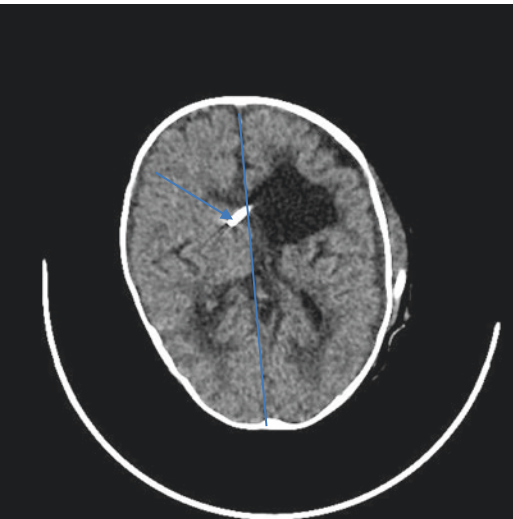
CT image after revision of left VP shunt. Arrow indicating shunt entering to left ventricle. Moderate decrease in size of left porencephalic cyst and decreased mass effect and midline shift
